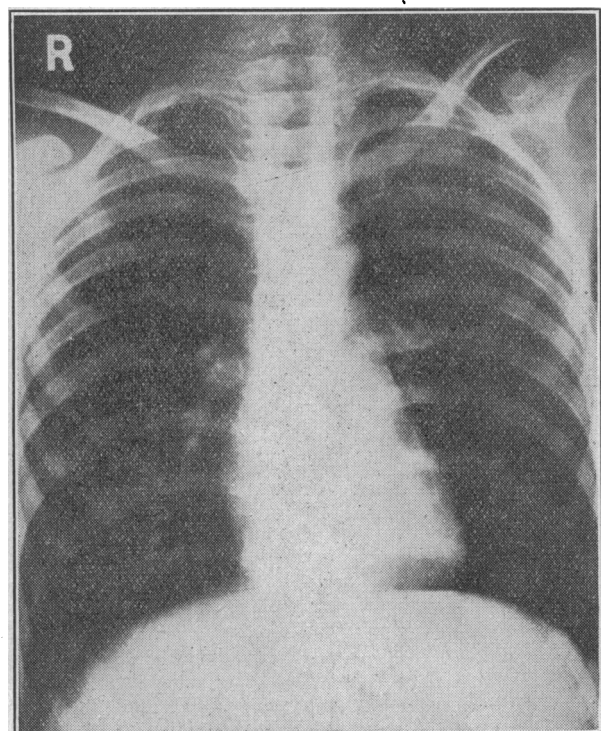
Case 1. Chest radiograph after treatment. The heart is now normal in size.
